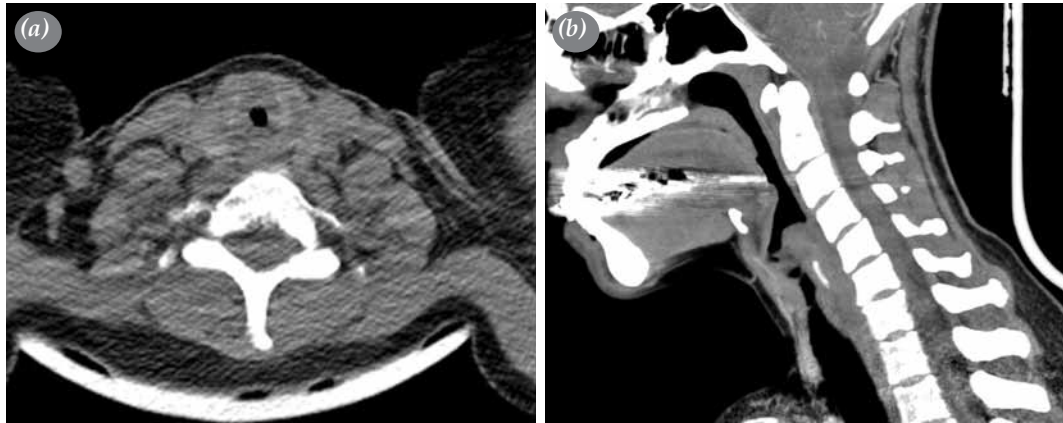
Cervical computed tomographic view showing (a) the transverse plane and (b) the sagittal plane.
